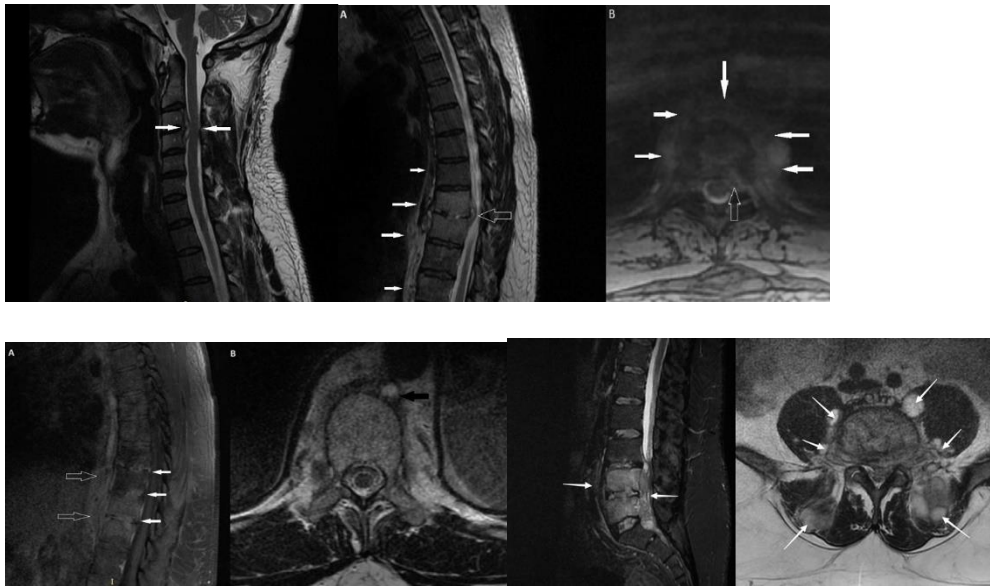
A – T2-weighted FSE sequence MRI of the cervical spine in the sagittal plane.
